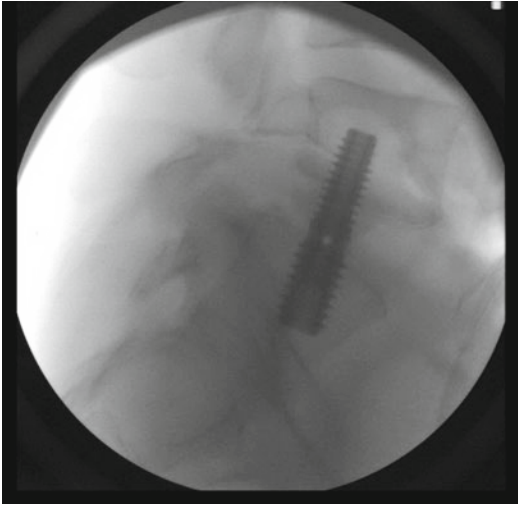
Intraoperative lateral x-ray demonstrating the successful placement of a L5–S1 interbody graft via the minimally invasive presacral approach
